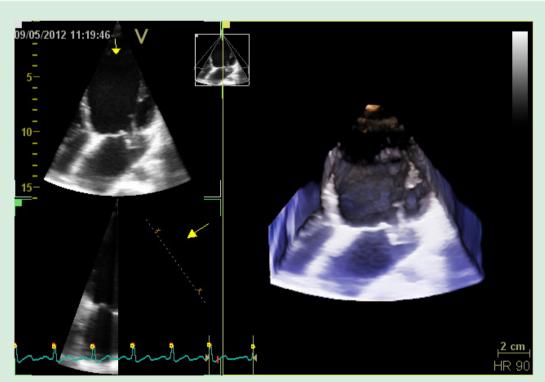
Three-dimensional transthoracic echocardiography. Echogenic image inside the left atrium, which is compatible with flail of anterior leaflet, arising from partial rupture of the anterolateral papillary muscle.
